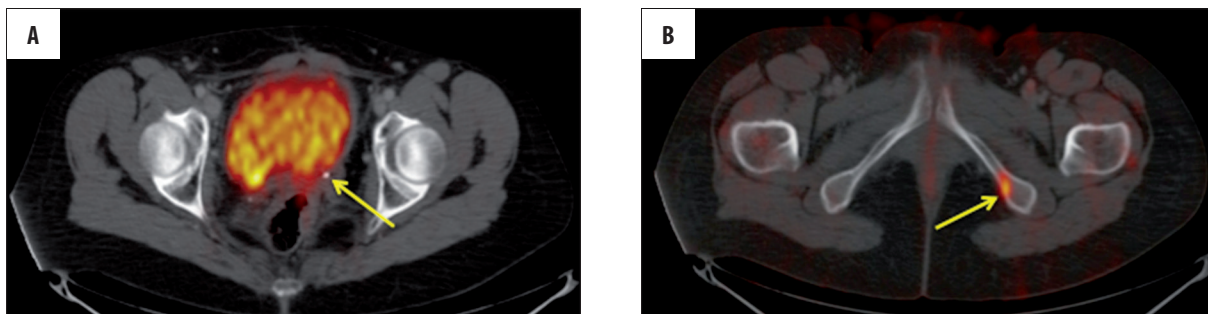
(A) Axial PET-CT image showing abnormal tissue in the posterior wall of the bladder with increased FDG uptake (SUV max 7), (B) Axial PET-CT image also demonstrated abnormal uptake (SUV max 5.2) in a millimetre osteolytic focus in the left ischio-pubic branch.
